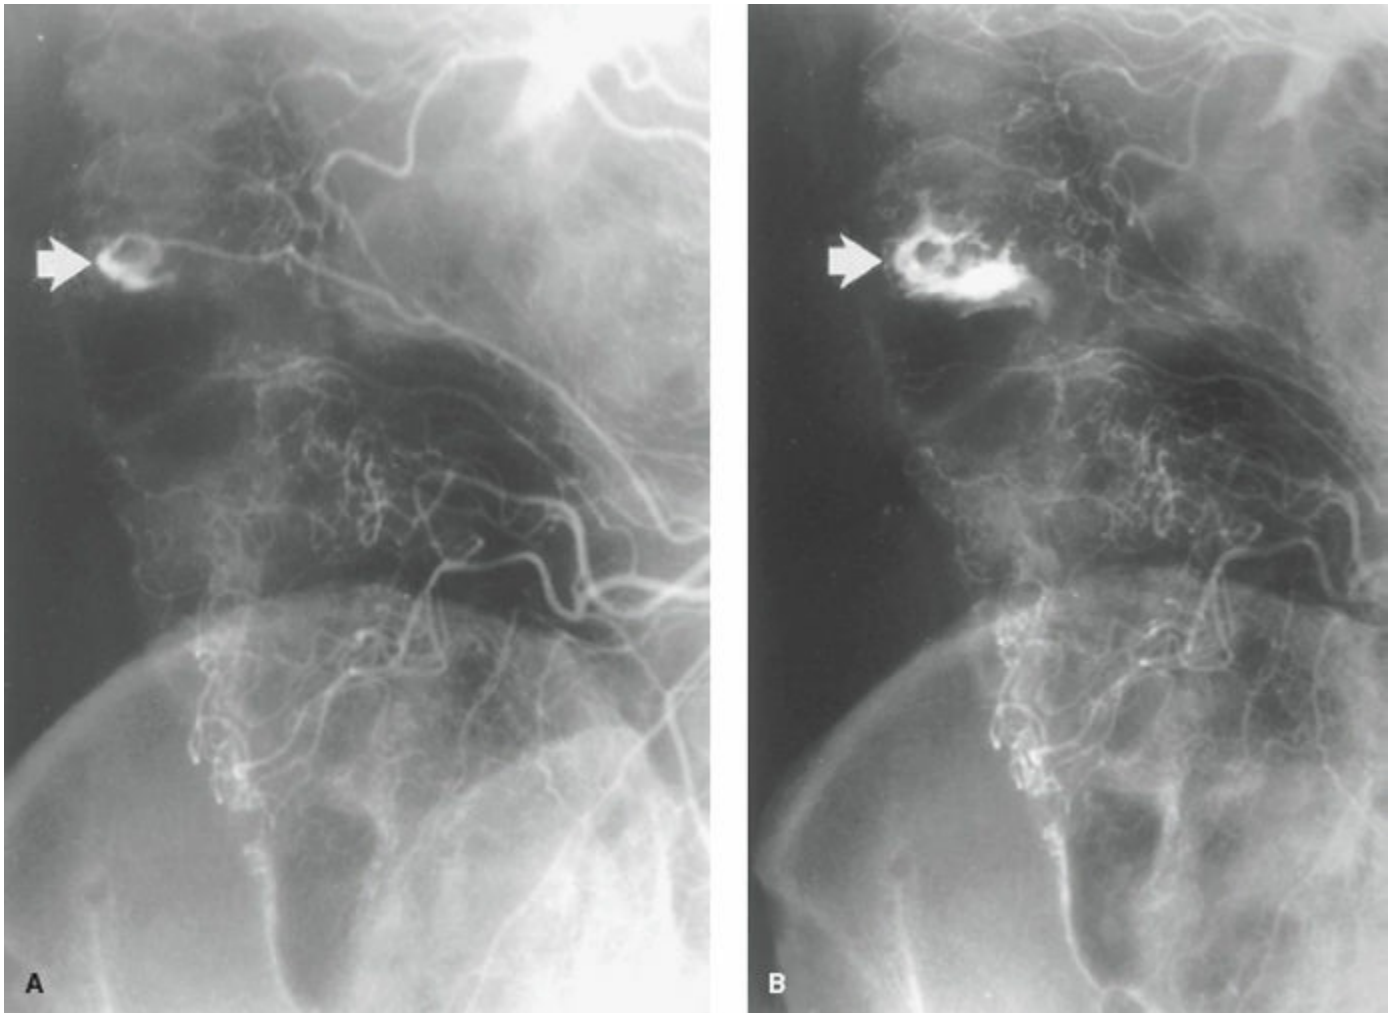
Superior mesenteric arteriogram from a patient with bleeding from a right colon diverticulum. A: Early radiograph with contrast material outlining the diverticulum (*arrow*). B: Late radiograph demonstrating overflow of contrast material into the colonic lumen(*arrow*).
